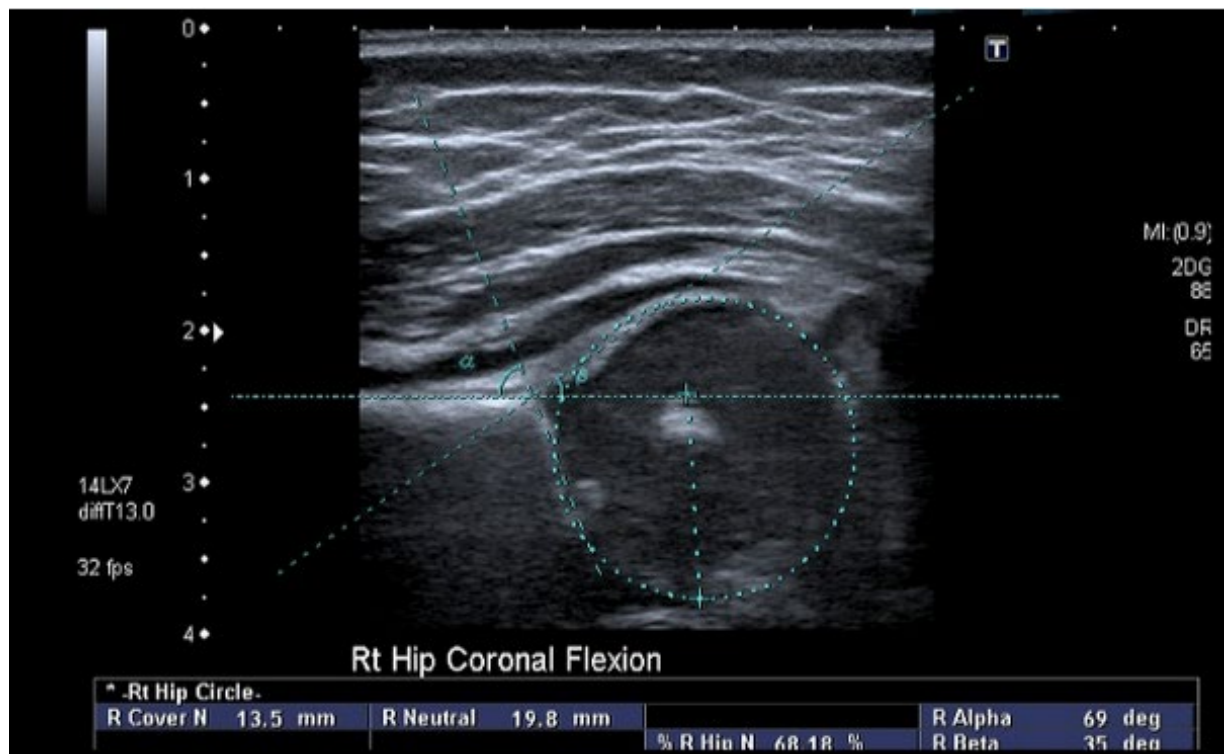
Graf ultrasound with measurements - normal hip with developing ossification centre
